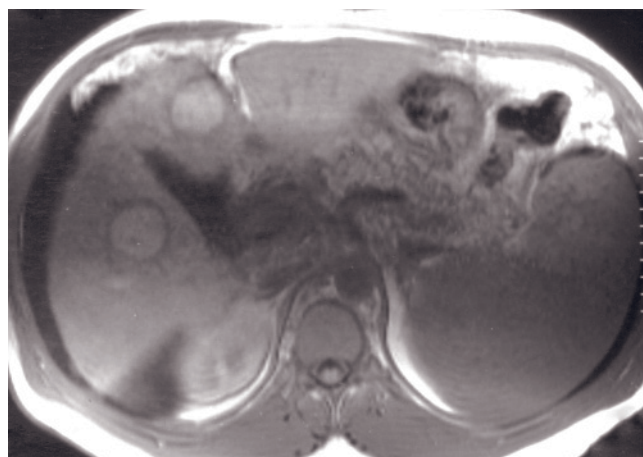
Hepatocellular carcinoma, multifocal with high signal intensity, not representing fat, on T1-weighted images. SGE (a), out-of-phase SGE (b), fat-suppressed T2-weighted ETSE (c), and immediate (d) postgadolinium SGE images. Multiple HCCs are present that are high in signal intensity on T1 in-phase images (arrows, a) and do not drop in signal or develop a phase-cancellation artifact on the out-of-phase image (b), which excludes the presence of fat. The small HCCs are isointense with liver on T2 (c), whereas the large tumor is heterogeneous and mildly hyperintense. On the immediate postgadolinium image (d), the small HCCs exhibit predominantly peripheral enhancement, whereas the larger HCC has diffuse heterogeneous enhancement. A low-signal-intensity pseudocapsule is appreciated around the larger HCC on all imaging sequences.
